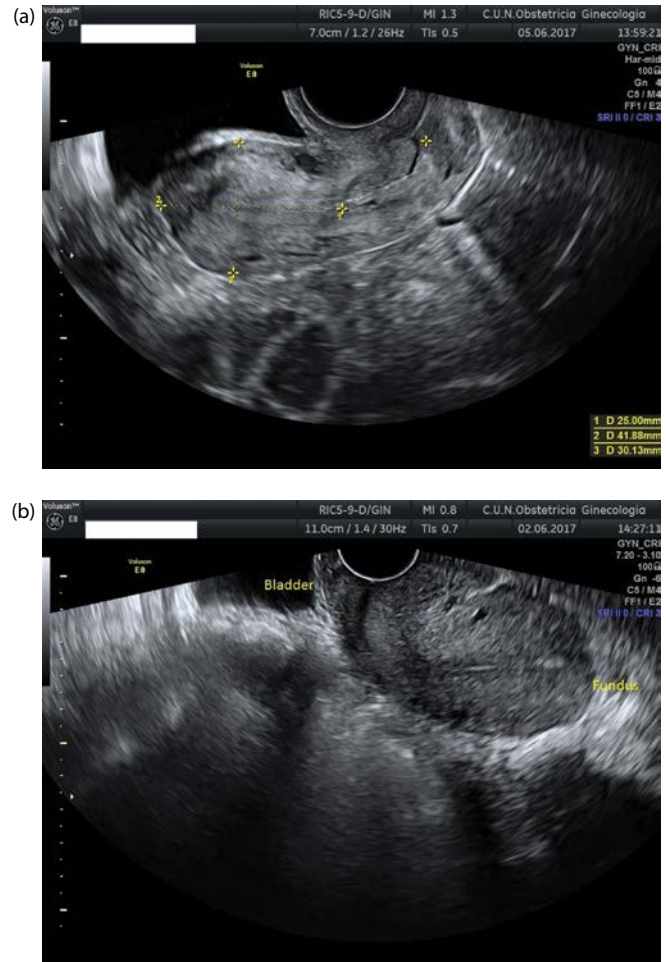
(a) Transvaginal ultrasound showing a uterus in its longitudinal plane. This uterus is anteverted. Measurements of the cervical length, corpus uteri length, and corpus uteri anterior-posterior diameter can be observed. (b) Transvaginal ultrasound showing a retroverted uterus. The fundus is located away from the bladder, to the rectum.
